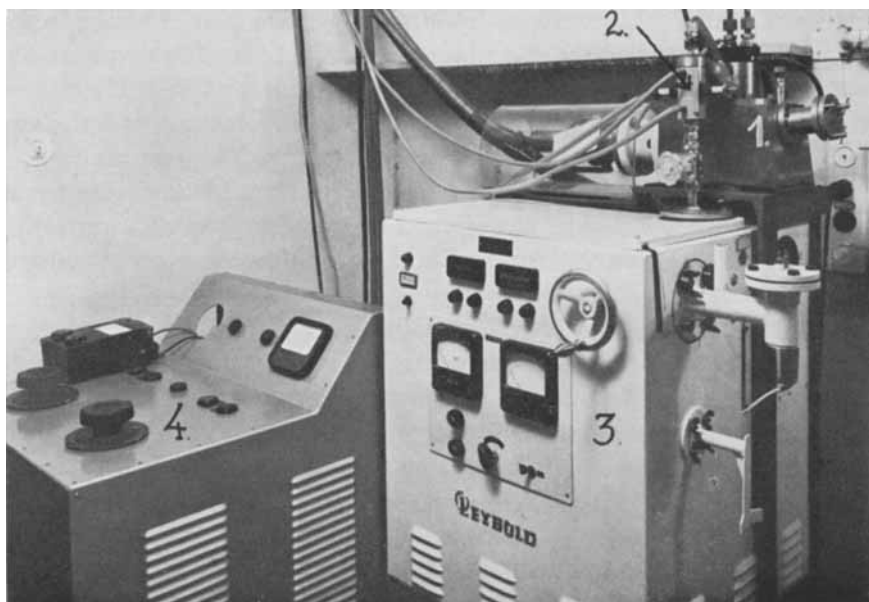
Photograph of the roentgen tubes (1 and 2), the vacuum system (3), and the high voltage supply (4) used in the historadiographic studies.
